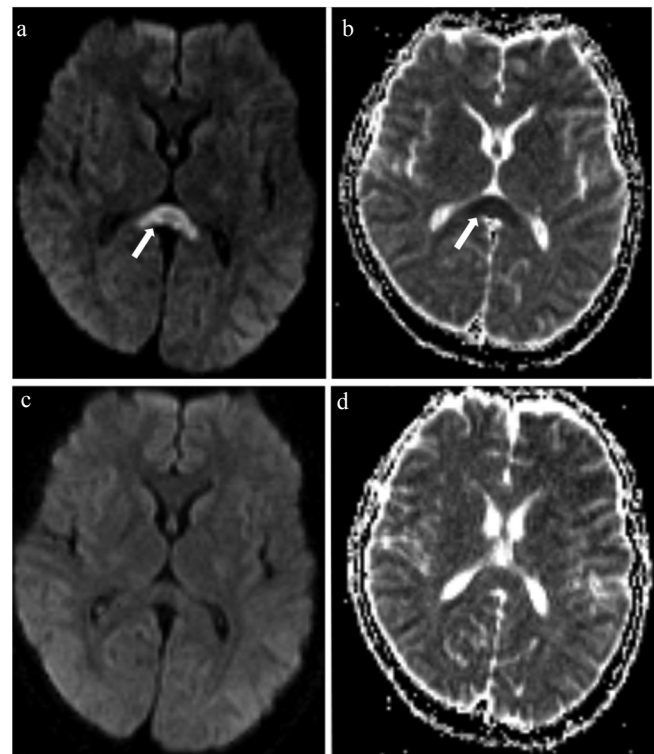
Magnetic resonance images from a 23-year-old man presenting with headache. (a and b) Axial DWI and ADC map showing reduced diffusion in the splenium (arrows), which is a typical MERS type I presentation. There is no visible reduced diffusion in the genu. (c and d) Follow-up axial DWI and ADC map after 10 days of symptomatic treatment, showing that the lesions had disappeared. DWI: diffusion-weighted imaging; ADC: apparent diffusion coefficient; MERS, mild encephalitis/encephalopathy with a reversible splenial.
